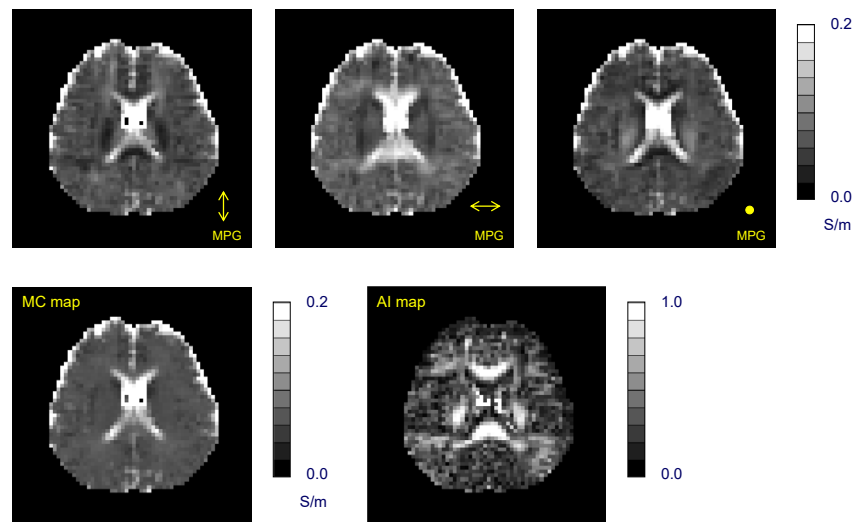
Conductivity images of the human subject obtained by the diffusion MRI. In upper three figures, images from the left to the right are the estimated conductivity distributions in the anterior-posterior, right-left, and superior-inferior directions, respectively, in the MPG. In the lower two figures, image of the MC in the left side, and image of the AI in the right side, are shown.
